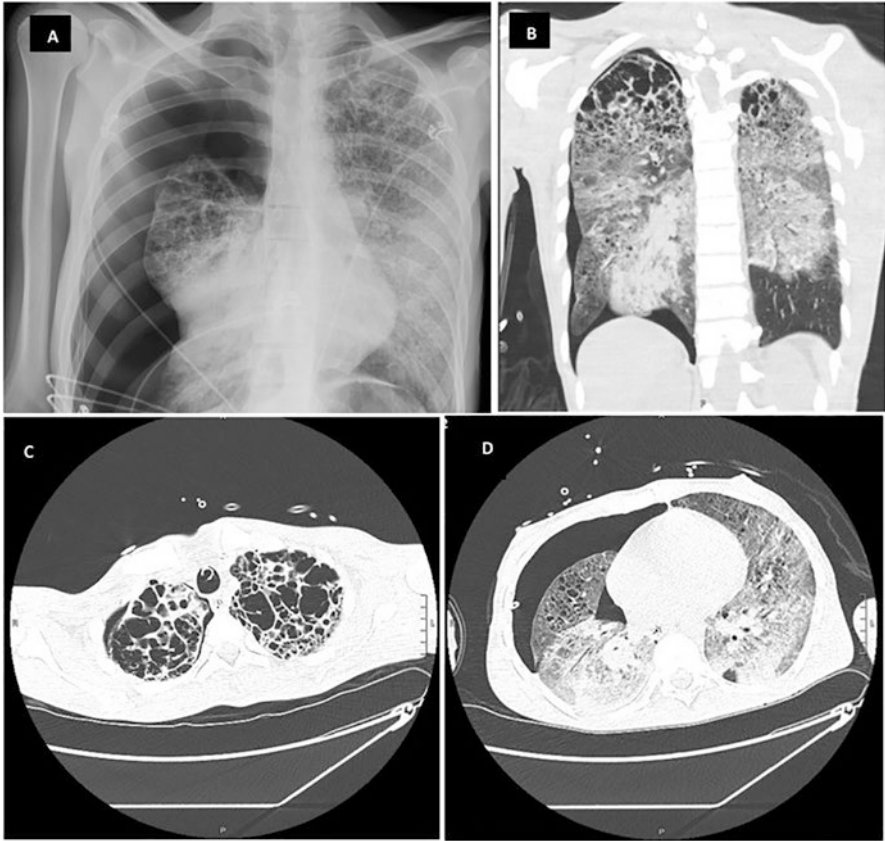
Depicting a chest X-ray and a CT scan of the chest at the time of presentation, (a) X-ray of the chest reveals a massive right pneumothorax and severe interstitial illness, (b) Coronal CT chest picture demonstrating apical cystic alterations, diffuse ground-glass opacities, thick consolidation, and pneumothorax, (c) An axial image of the most prominent apical cystic alterations, and (d) Axial image with the chest tube revealing diffuse ground-glass opacities and a right pneumothorax, reproduced with permission [28]. (continue directly)
